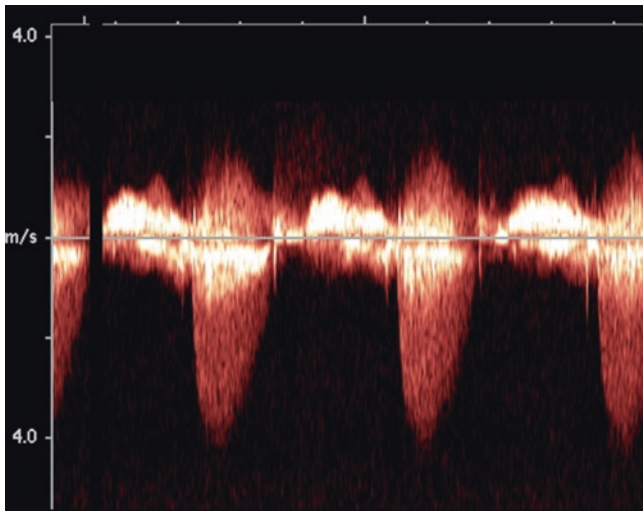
Interrogation of the aortic valve using continuous wave spectral Doppler. The examination shows a high transaortic flow velocity (approximately 4 m/sec) consistent with severe aortic stenosis. Interpretation of the Doppler findings requires excellent ultrasound examination and interpretation skills. The velocity can be underestimated if a single acoustic window is used. The flow signal should not be confused with other flows (like mitral regurgitation). Also, other causes of left ventricular outflow obstruction can cause elevated transaortic velocities; these include hypertrophic obstructive cardiomyopathy, sub-aortic membrane, and supra-ventricular obstruction
